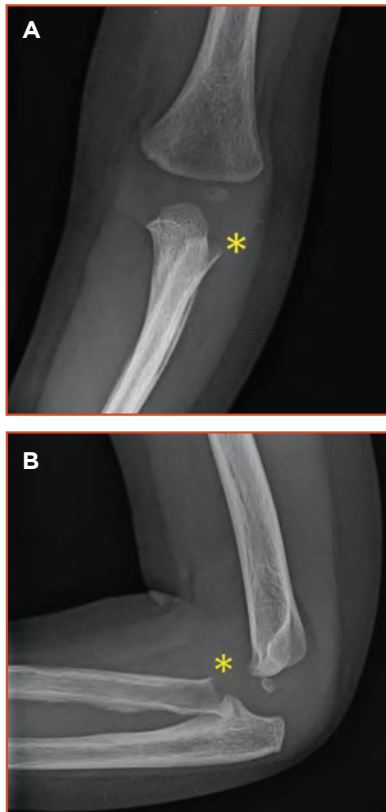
A) Anteroposterior and B) lateral radiographs at time of admission, showing osteolysis of the proximal radius (asterisk).
